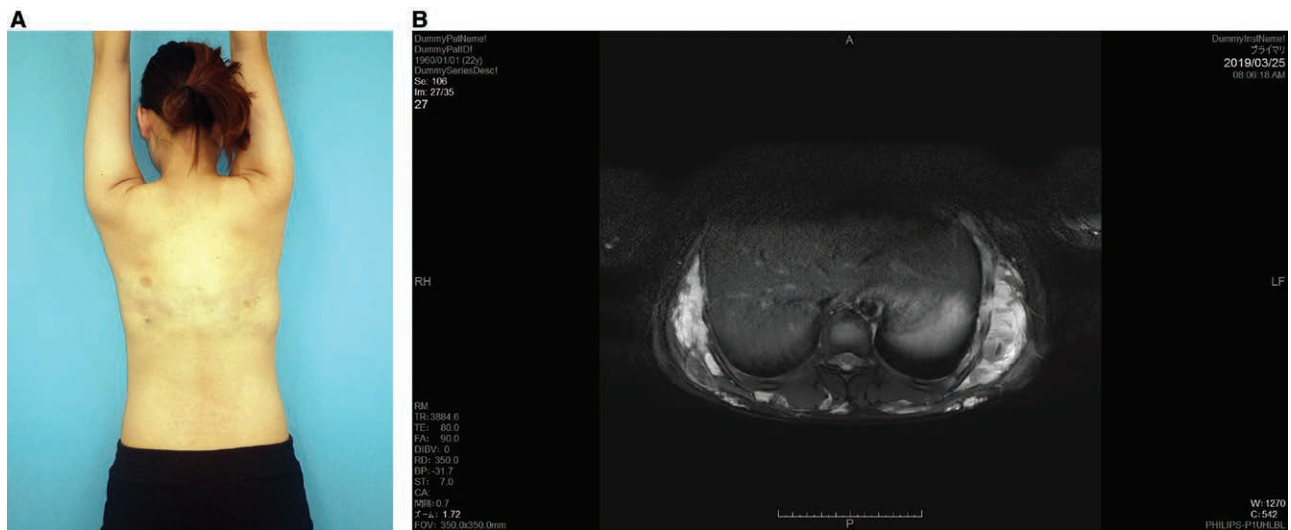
Post-treatment findings. A, One year after the 4 treatment sessions, there is marked regression of the lesion without scarring or contracture. B, MRI 6 months after the 4 treatment sessions, showing regression of the lesion (arrowheads). Satisfactory regression without scarring and contracture was achieved in venous malformation treated with ILP. Video Ultrasound B mode image of the vascular lesion during ILP laser irradiation of the vascular lesion through the inserted fiber. An increase in the US signal density is observed at the fiber tip.
